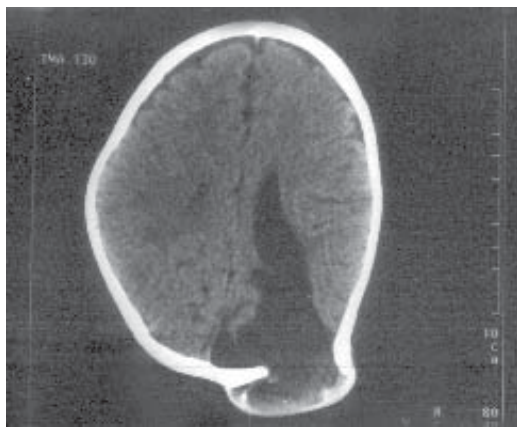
Axial CT section showing defect in the skull with a cystic lesion pushing through and communicating with the left lateral ventricle. Also noted is widening of the sulcal spaces.
